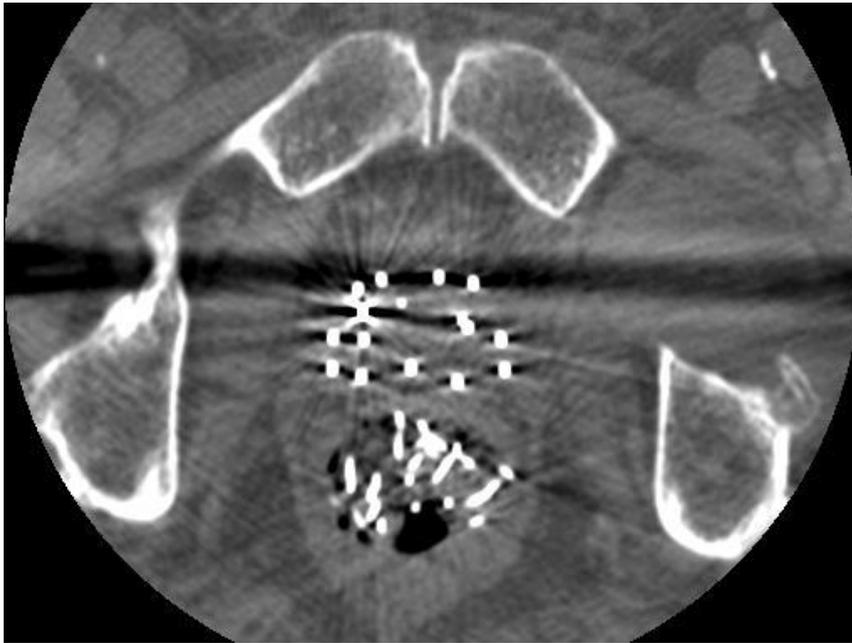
CT slice from 15th patient at SCGH (GE Lightspeed VCT, 140 keV, auto mAs. FOV 181x181 mm, 512x512 array, 16 bit grey-scale, 0.625 mm slice thickness, ‘soft tissue’ filter). Slice shows implanted needles, fiducial markers, and wire ribbon in rectal packing.
